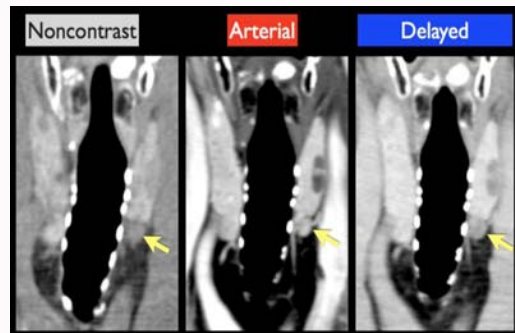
Four-dimensional computed tomography (4D-CT) scan. An oval shaped enhancing mass with low attenuation on non-contrast phase relative to thyroid (Yellow arrow). The greatest attenuation is in the arterial phase and rapid washout of contrast in the delayed phase Yellow arrow. There are variations in enhancement patterns and helpful morphological findings such as the polar vessel (White arrow) seen in the arterial phase [4,5].
